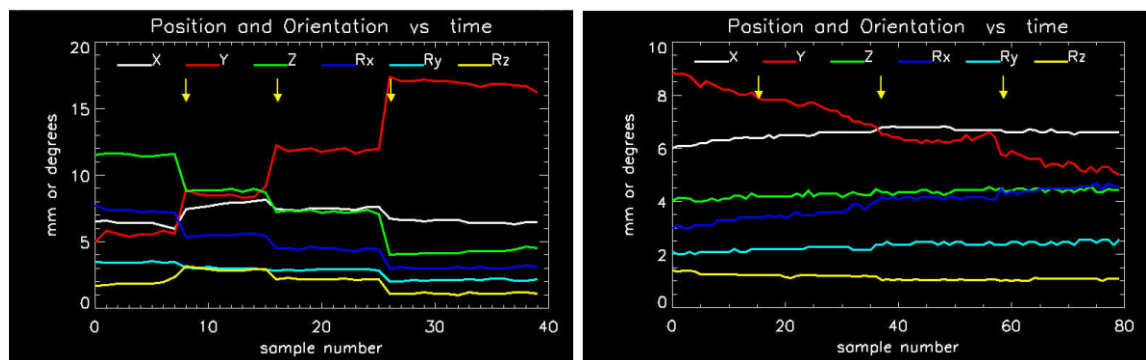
Polaris motion traces measured for two minimally constrained patients during a 30-minute brain SPECT study. The colour coding is the same as that in Figures 6.10 and 6.11. Left: The first patient demonstrated distinct changes in mean head location at multiple times throughout the acquisition. It is this type of motion we have sought to reproduce and correct for in our volunteer studies. The yellow arrows indicate user-selected samples between which the change in head location will be computed. Right: the second patient demonstrated gradual drifting motion (particularly y-translational) similar to that observed in our volunteers. Here, yellow arrows indicate samples at which the study may be segmented in order to approximate motion as a series of discrete steps. Both of these types of motion present themselves in the clinical setting. Data is courtesy of Leighton Barnden, Queen Elizabeth Hospital, Adelaide.
